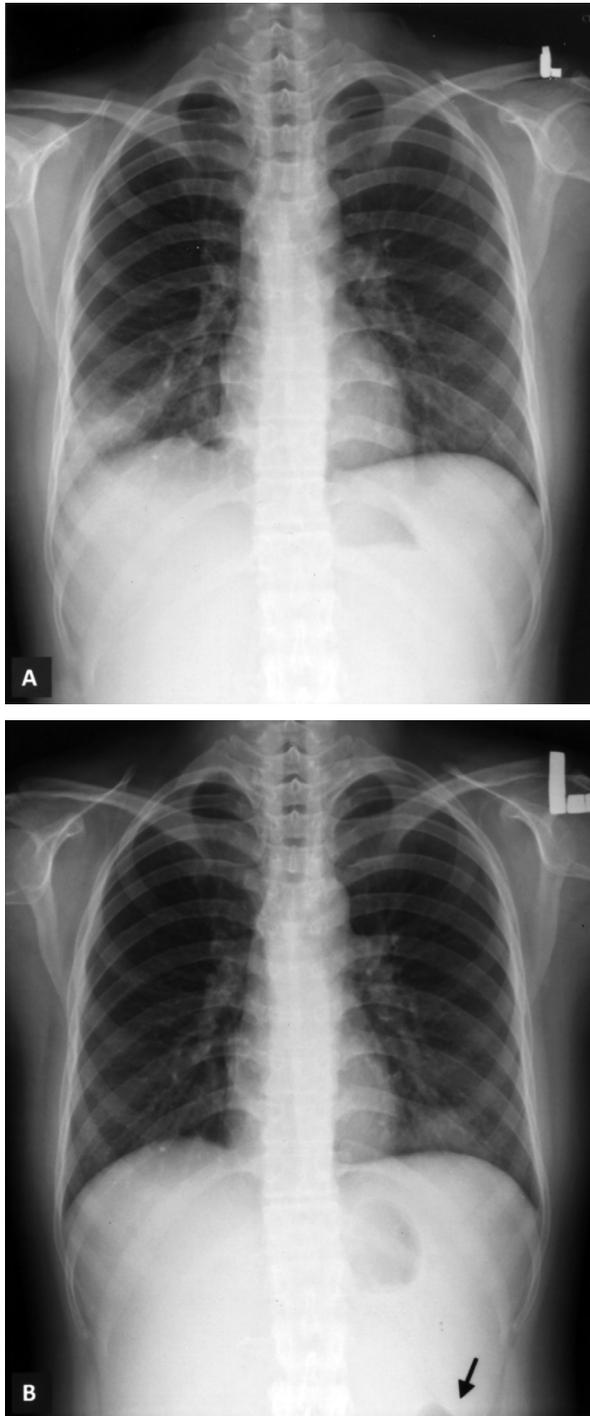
A 24-year-old woman had with migratory pneumonia within 3 months with different causal microorganisms as pneumococcus in the right lower lobe (A) and *Haemophilus influenzae* in the left lower lobe (B). Splenomegaly was identified on the 2nd chest radiography (B, arrows). After intravenous immunoglobulin replacement for her CVID, regression of splenomegaly could be detected on the follow-up chest film (C, arrowhead).
